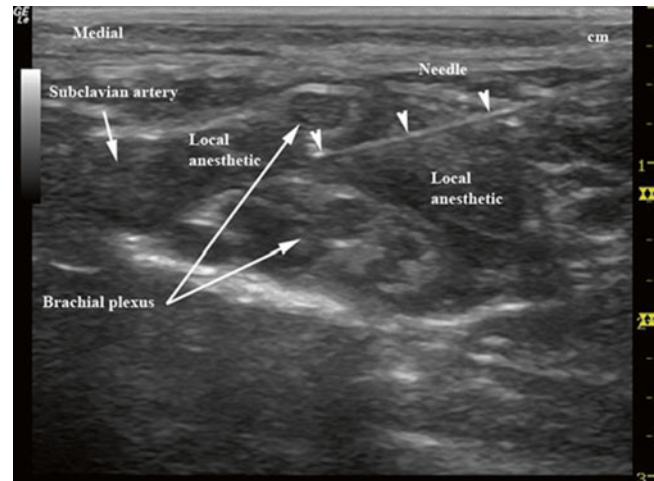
In-plane needle placement for the supraclavicular block with ultrasound. Local anesthetic has been dynamically placed to surround the brachial plexus (With permission from Buckenmaier and Bleckner [71])
